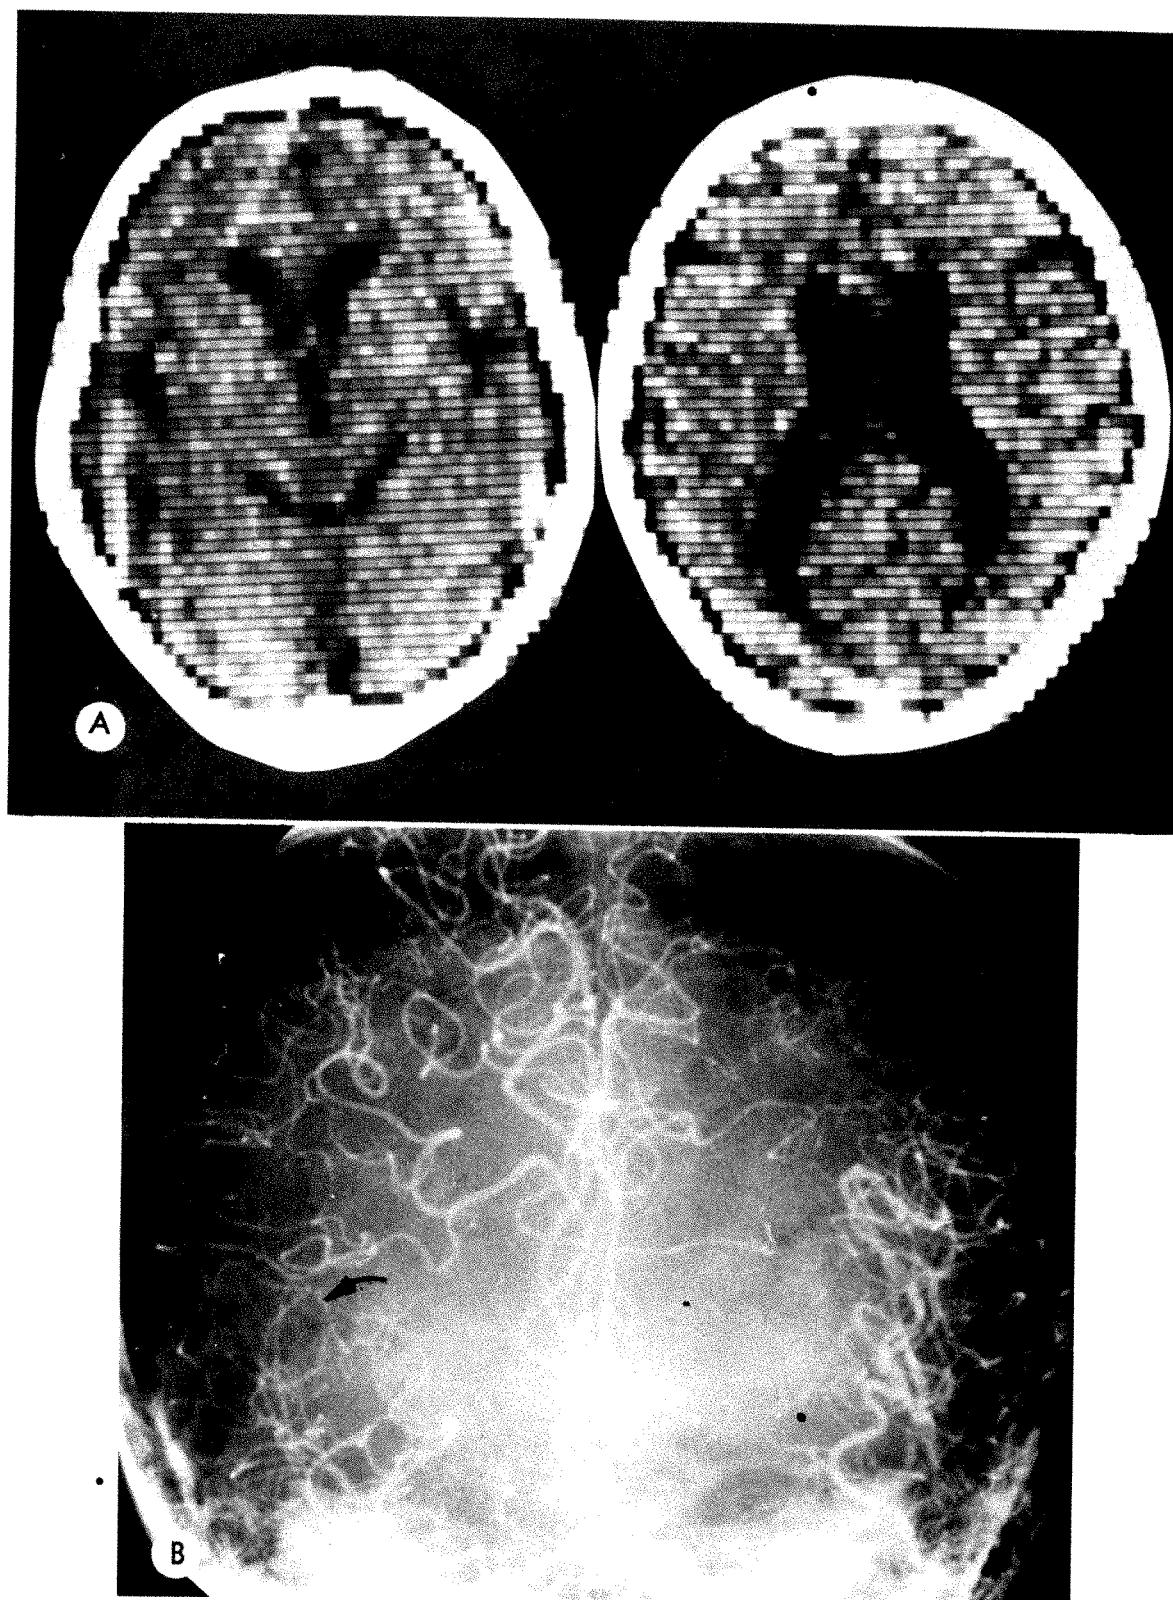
Arteriosclerotic vascular occlusive disease. *A*, CT scans showing minimal atrophy only. *B*, Left carotid AP angiogram showing retrograde filling from right anterior cerebral artery into right middle cerebral artery (*arrow*).
